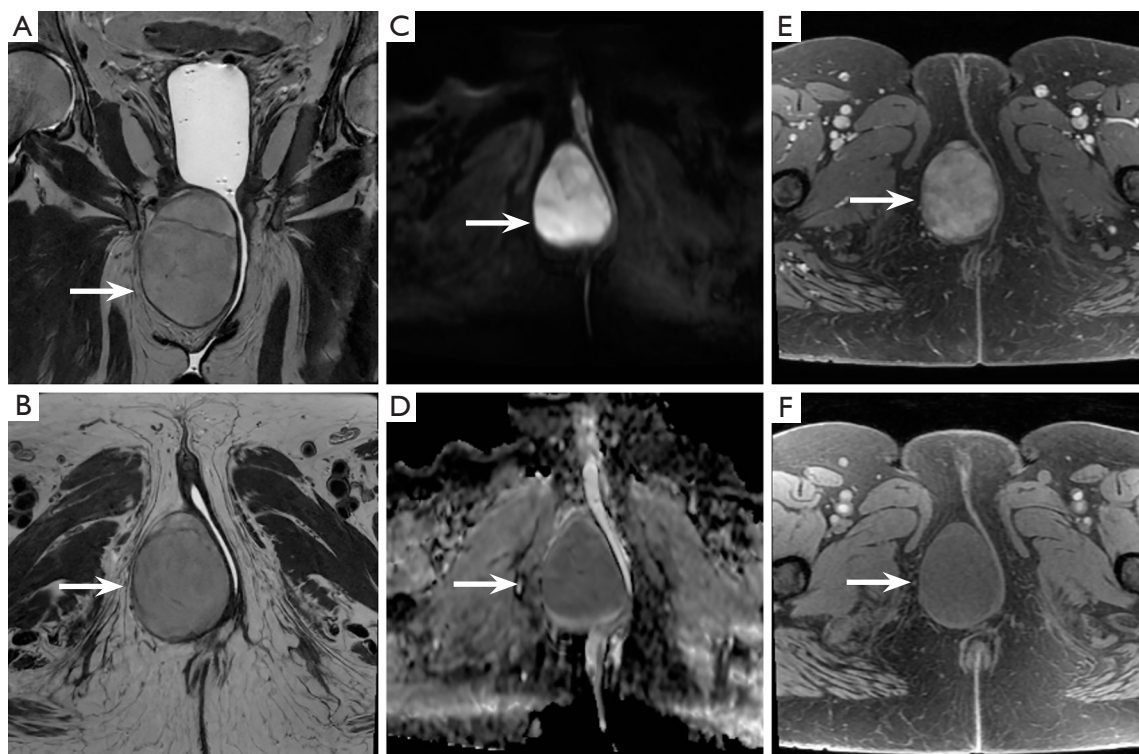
Subcutaneous vulvar neoplastic lesion. MRI with IVC and intravaginal gel shows a right subcutaneous lesion (white arrows) abutting the vaginal wall without invasion. (A,B) Intermediate T2 signal; (C,D) restricted diffusion; (E,F) heterogeneous enhancement. IVC, intravenous contrast; MRI, magnetic resonance imaging.
